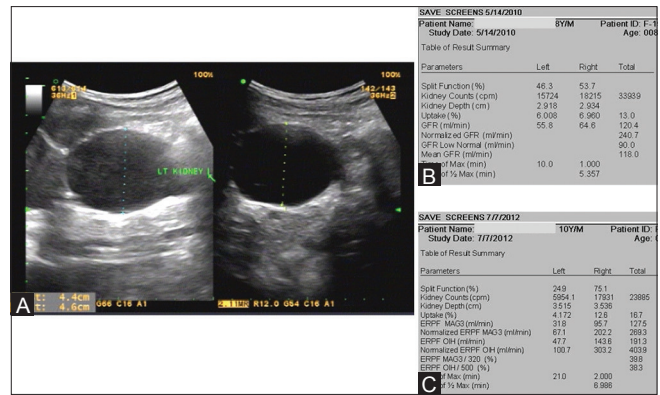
(A-C): (A) Post-pyeloplasty ultrasound showing APD of left kidney in supine 44 mm and in prone position 46 mm (B) Pre-pyeloplasty renogram showing 46% differential function of left kidney (C) Post-pyeloplasty renogram showing 24.9% differential function of left kidney, indicating obstruction
